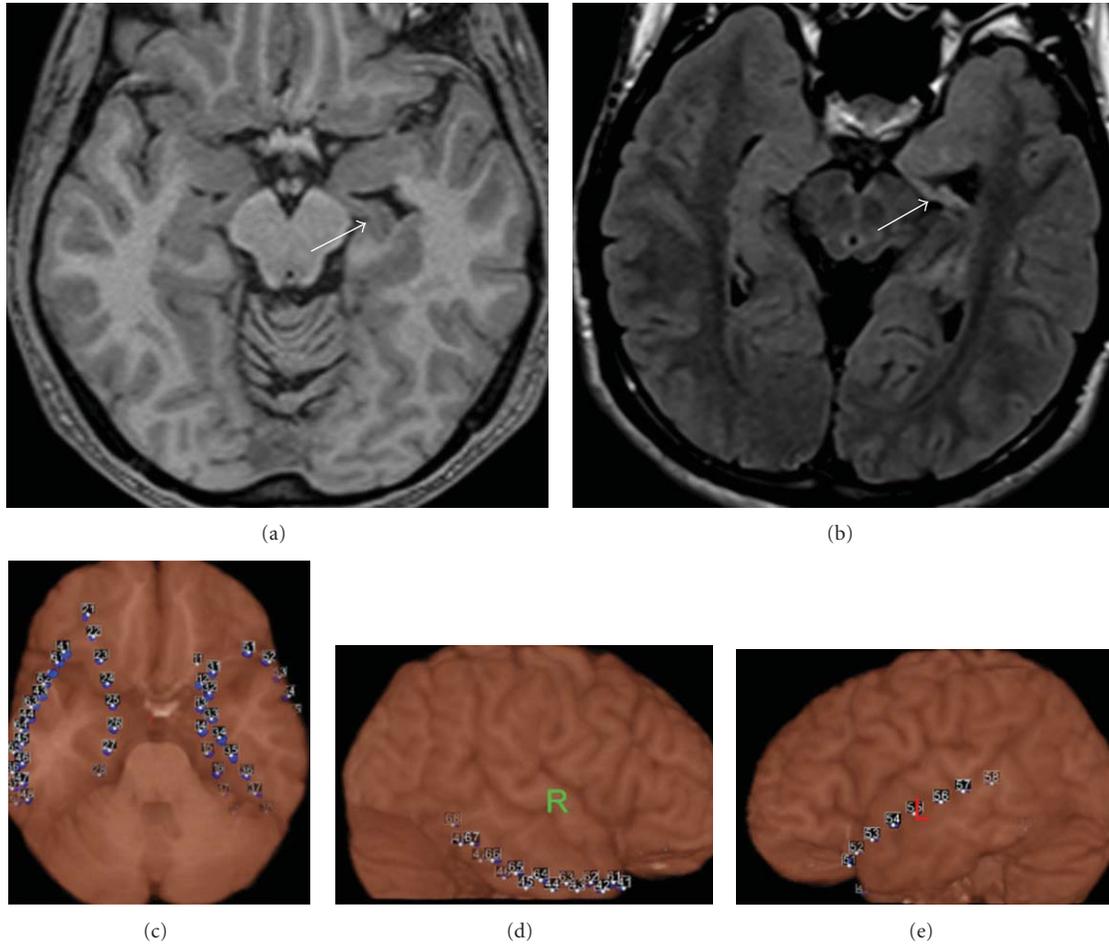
(Case 5) MRI of the brain in a patient with refractory complex partial seizures shows severe left MTS (upper). Atami Epilepsy Viewer image of bilateral subdural lines placed for invasive monitoring (lower).
